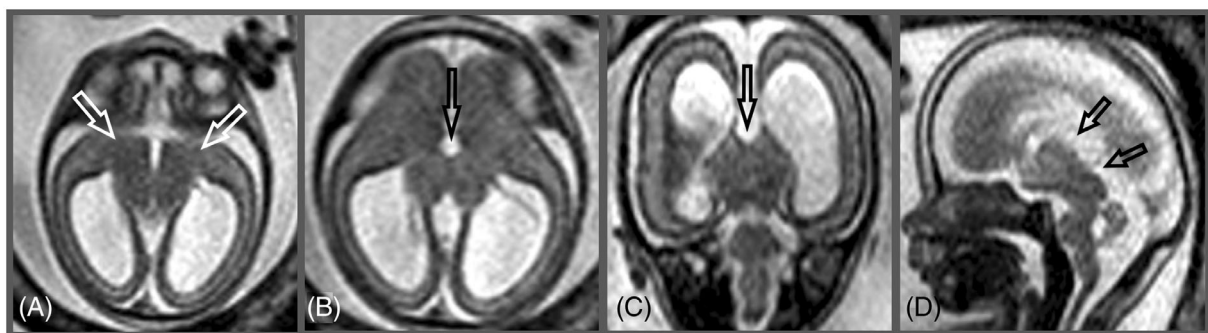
Diencephalic-mesencephalic junction dysplasia in a 21 GW fetus with partial corpus callosum agenesis and L1 syndrome. (A) Axial T2-weighted image shows enlarged dorsoventral size of the brainstem and abnormal midbrain contour in the axial plane, with ventral cleft, forming the butterfly sign (white arrows). (B) Axial and (C) coronal T2-weighted images show midline fusion of the thalami, or diencephalosynapsis (arrow), ventriculomegaly, and corpus callosum agenesis; (D) sagittal T2-weighted image shows lack of separation between the massa intermedia of the thalamus and the midbrain (arrows)
